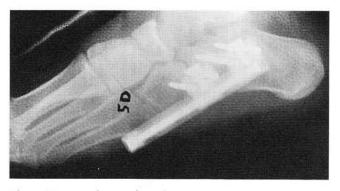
Lateral view of initial x-ray.
